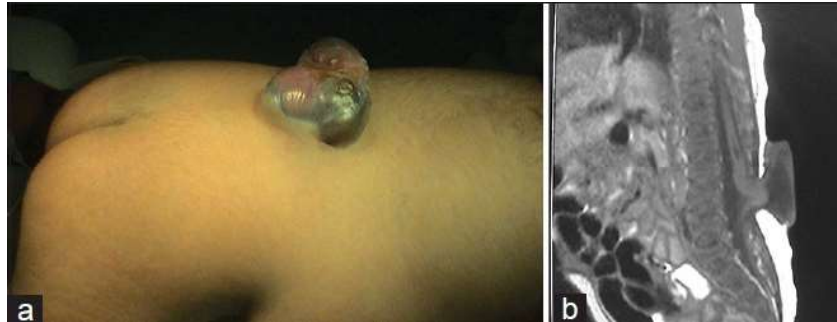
Clinical photo of a child with myelomeningocele (A) with corresponding MRI (B). (Image courtesy Bao N, Lazareff J. How I Do It: Management of spina bifida in a hospital in The People's Republic of China. *Surg Neurol Int* 23-Jul-2015;6)
